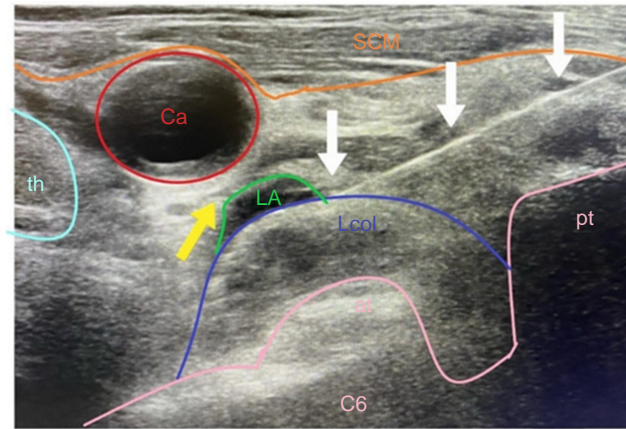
Ultrasound-guided continuous percutaneous left stellate ganglion block at C6 level. at, anterior tubercle; ca, carotid artery; LA, local anaesthetic; Lcol, longus colli muscle; pt, posterior tubercle; scm, sternocleidomastoid muscle; th, thyroid; white arrows, needle's position; yellow arrow, target region.
